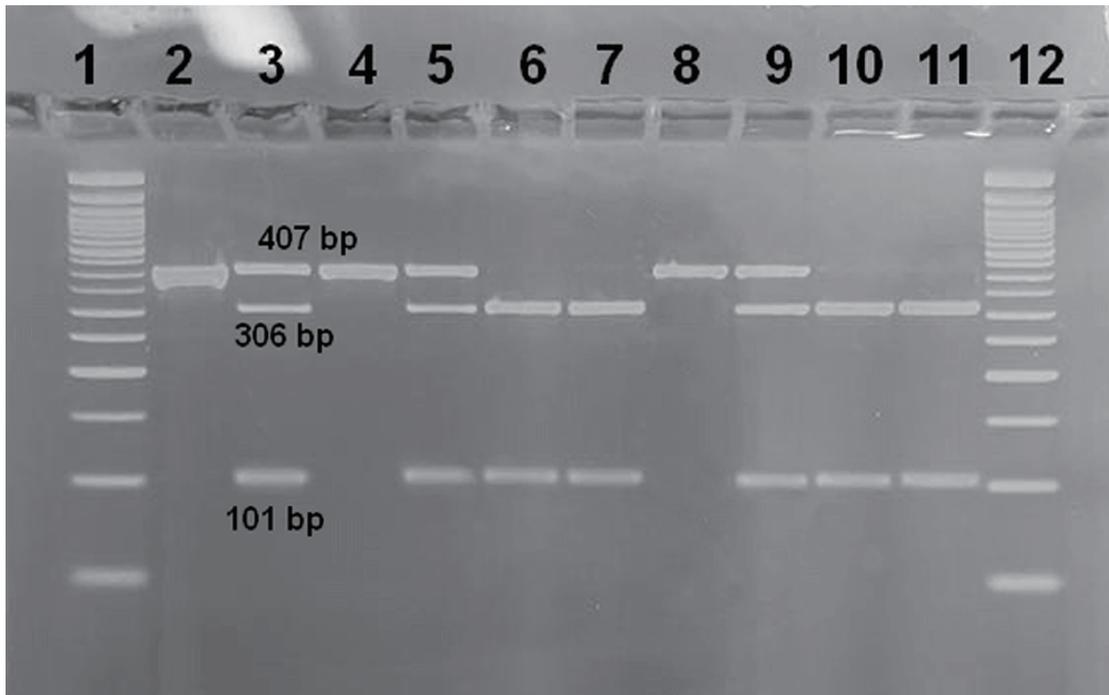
Agarose gel showing RFLP analysis of the *TNFSF15* rs4979462 variant. Lanes 1 and 12 show 50 bp DNA ladder; Lane 2 shows the 407-bp amplicon; Lanes 4 and 8 show the homozygous TT genotype; Lanes 3, 5, and 9 show the heterozygous CT genotype; Lanes 6, 7, 10, and 11 show the homozygous CC genotype. *TNFSF15*, TNF superfamily member 15; RFLP, restriction fragment length polymorphism.
